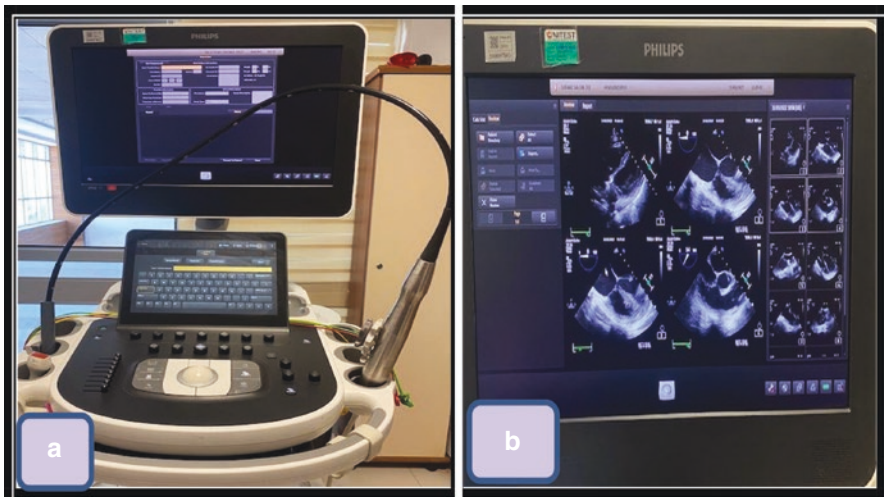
(a) Transesophageal echocardiography unit; (b) display of the transesophageal echocardiography unit
